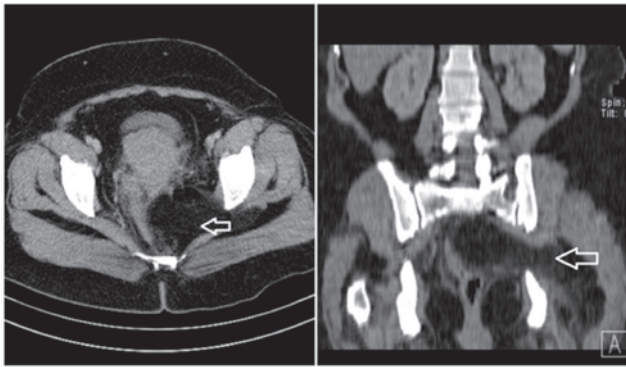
Plain CT scan showing the lipoma as a homogenous fat attenuation lesion with a faintly visible capsule in the left side of pelvis extending through the left sciatic foramen (arrow).
